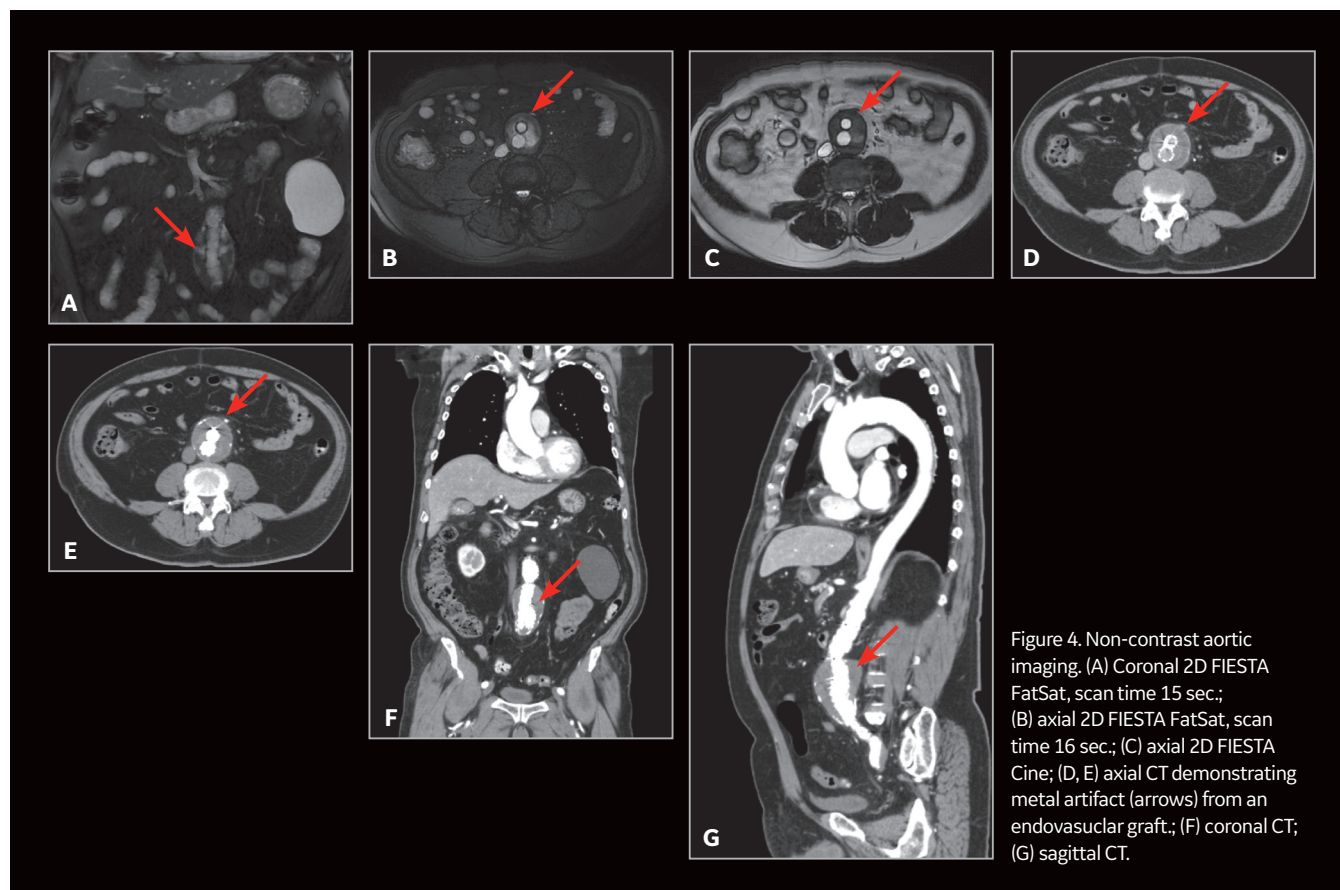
Non-contrast aortic imaging. (A) Coronal 2D FIESTA FatSat, scan time 15 sec.; (B) axial 2D FIESTA FatSat, scan time 16 sec.; (C) axial 2D FIESTA Cine; (D, E) axial CT demonstrating metal artifact (arrows) from an endovascular graft; (F) coronal CT; (G) sagittal CT.
